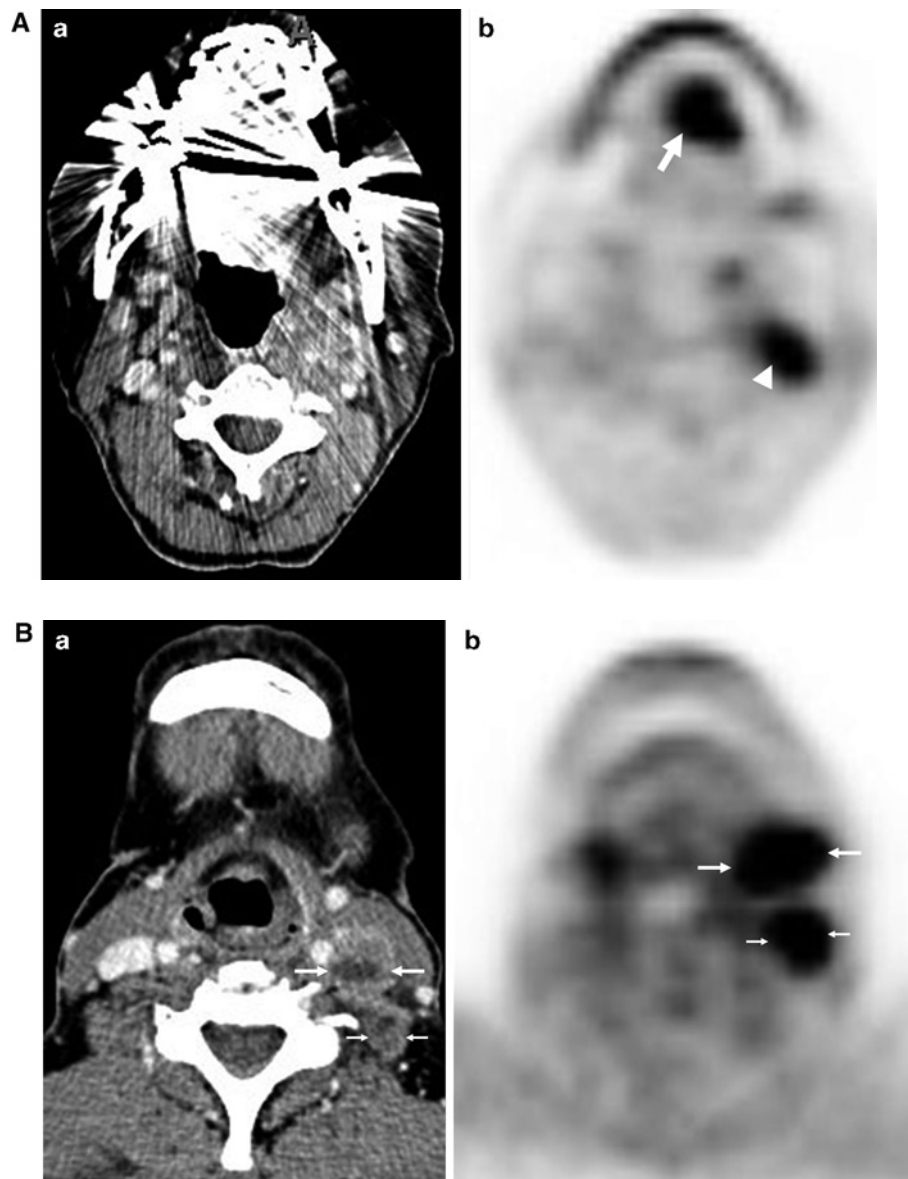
(A) a, b: Axial postcontrast CT scan (a) showing dense streak artifacts from unmovable dental hardware obscuring FDG-avid squamous cell cancer in the oral tongue (*arrow*) with metastatic left level 2 lymph node (*arrow head*) as seen on PET scan (b). (B) a, b: Axial postcontrast CT scan (a) showing large necrotic left level 2 lymph node (*large arrow*) and necrotic left level 5 lymph node (*small arrow*), with FDG avidity on the corresponding PET scan (b). (C) a, b, c: CT thorax in mediastinal windows (a), and lung windows (b) showing a metachronous lung cancer (*arrow*) with increased FDG uptake on PET scan (c)
